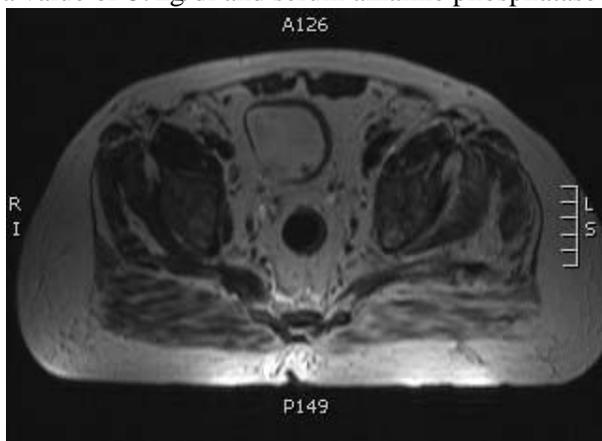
Axial MRI T2WI: posterior urinary bladder wall polyp
